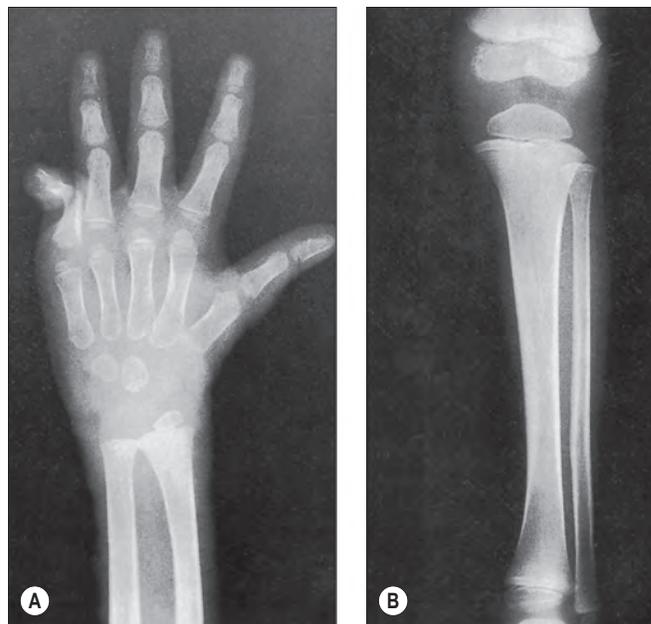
(A) At 6 months after injury, there is the coarsened trabeculation of marked osteoporosis of bones of the left hand and forearm of a 4-year-old boy whose 70% full-thickness burn involved the head, chest, and both upper extremities. (B) A radiograph of the left tibia and fibula obtained on the same date as that of the hand shows minimal atrophy.
